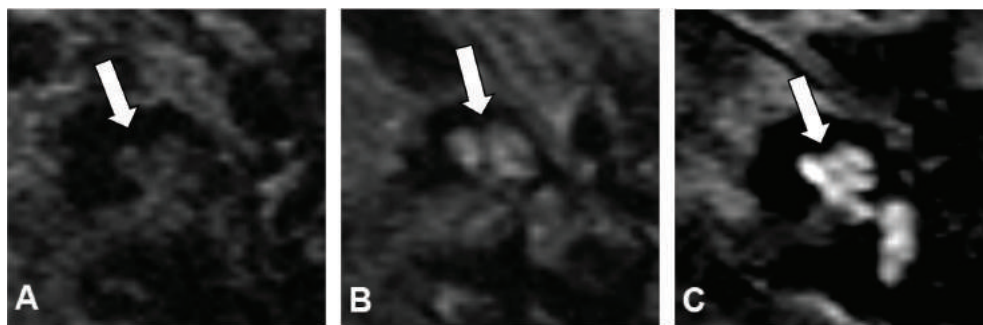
Grading of cochlear enhancement. Axial gadolinium enhanced T1-weighted MRI showing different grades of cochlear enhancement after contrast admission (arrows). A, Grade 0: no enhancement of the cochlea (Patient 14), B, Grade 1: moderate enhancement (Patient 9), C, Grade 2: severe cochlear enhancement (Patient 13).
